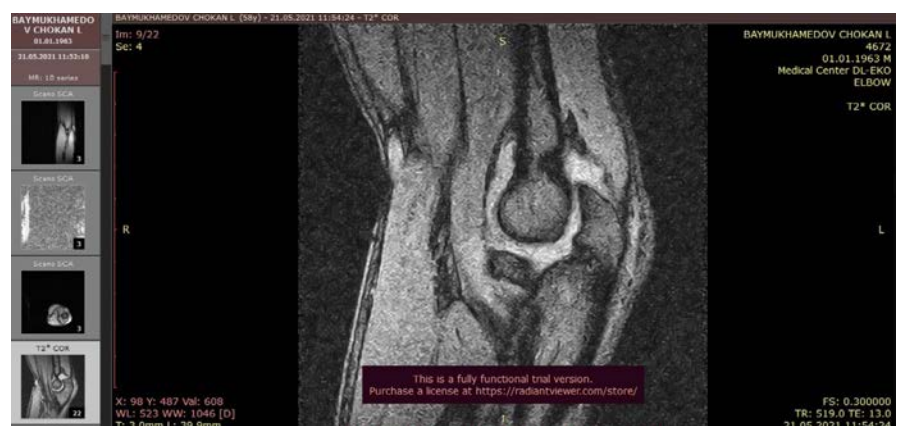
Magnetic resonance imaging showing elbow joint arthritis
